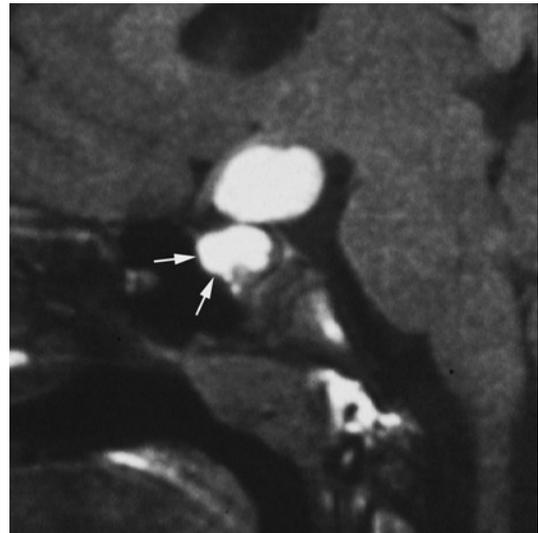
Sellar and suprasellar craniopharyngioma showing a double cystic component which has a bright signal on the T1-weighted sagittal plane (arrows)
